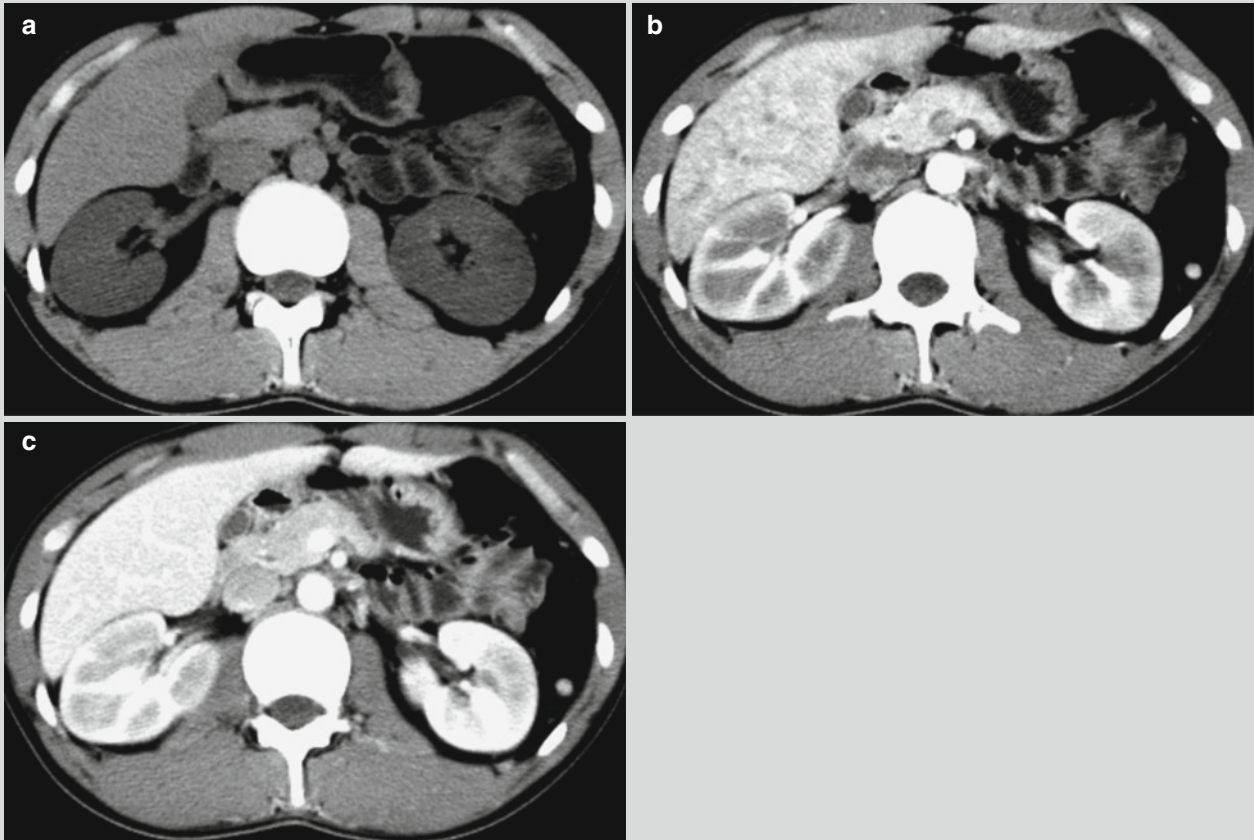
Renal malaria. (a) Plain CT scanning demonstrates decreased density of both kidneys and poorly defined corticomedullary interface. (b, c) Contrast scanning demonstrates enhancement of the lesions with patchy attenuation
